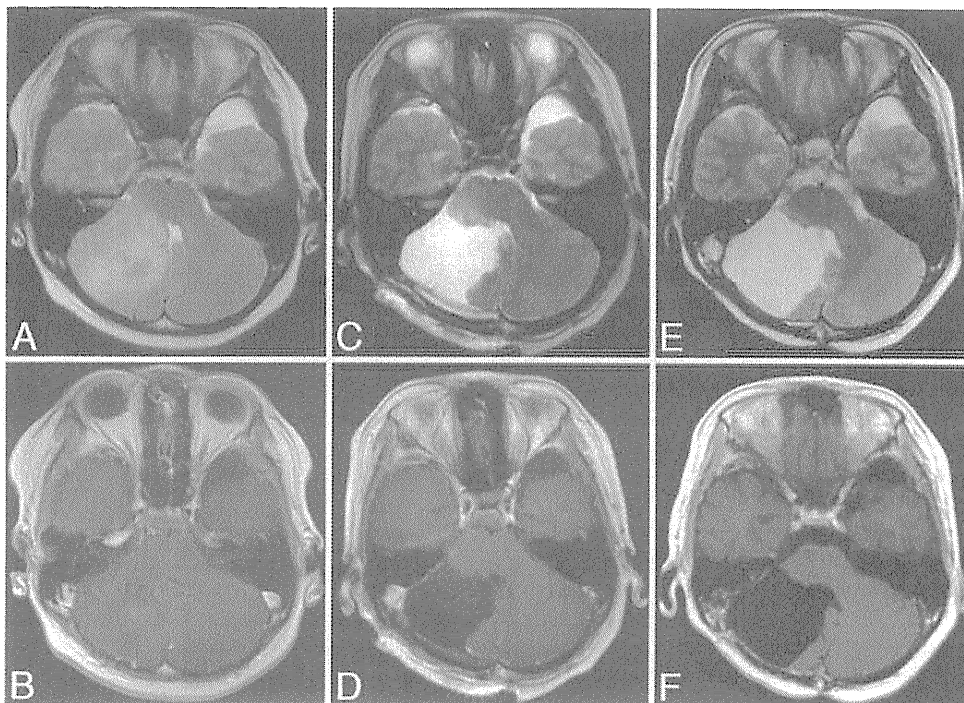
Axial T2-weighted (A, C, and E) and contrast-enhanced T1-weighted (B, D, and F) MR images obtained at diagnosis in October 2008 (A and B), after tumor resection (C and D), and at follow-up in May 2009 (E and F).
